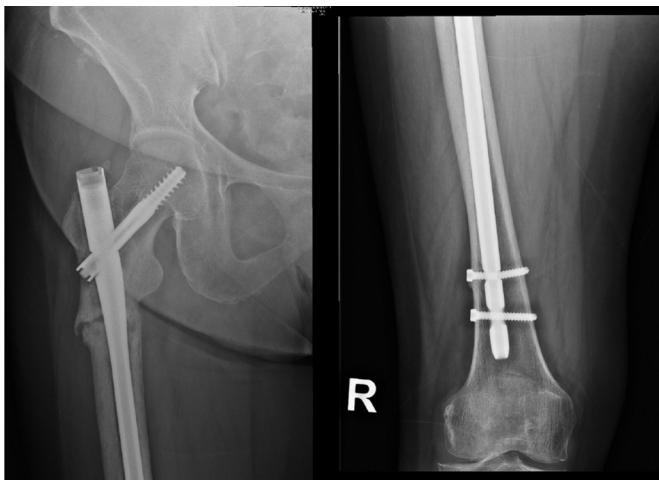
X-rays taken at 1 year post-operation showing non-union with breakage of the distal locking screw.
